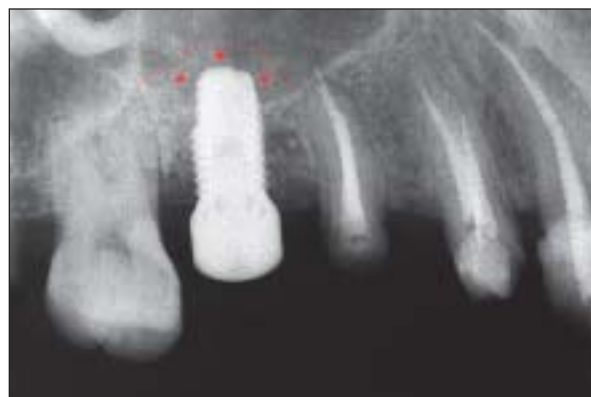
An immediate postoperative radiograph shows evidence of condensed bone around the implant and a light radiopacity indicative of the demineralized bone allograft (asterisks) placed at the apex of the implant. The dotted line indicates the displacement of the sinus floor.
